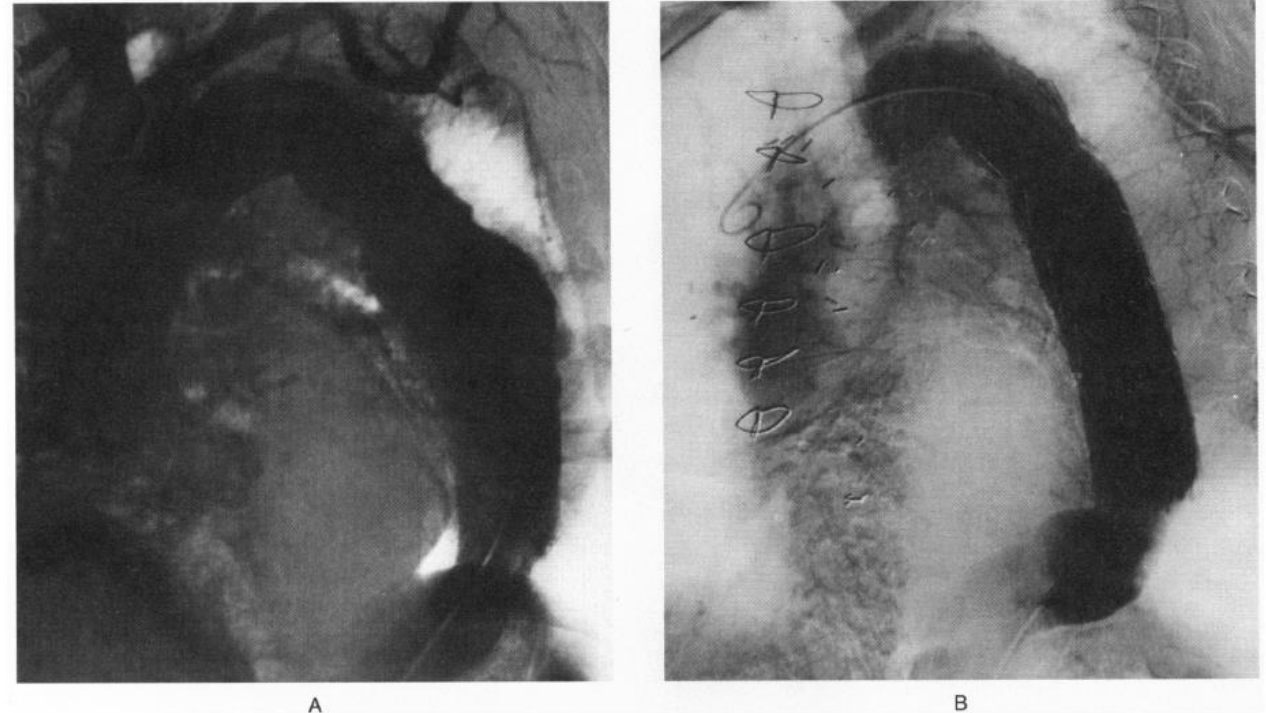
Left Anterior Oblique Views of the Aorta in a 71-Year-Old Woman (Patient 5) with Back Pain and an Abnormal Chest Radiograph Who Had Previously Undergone Coronary-Artery Bypass Grafting.
